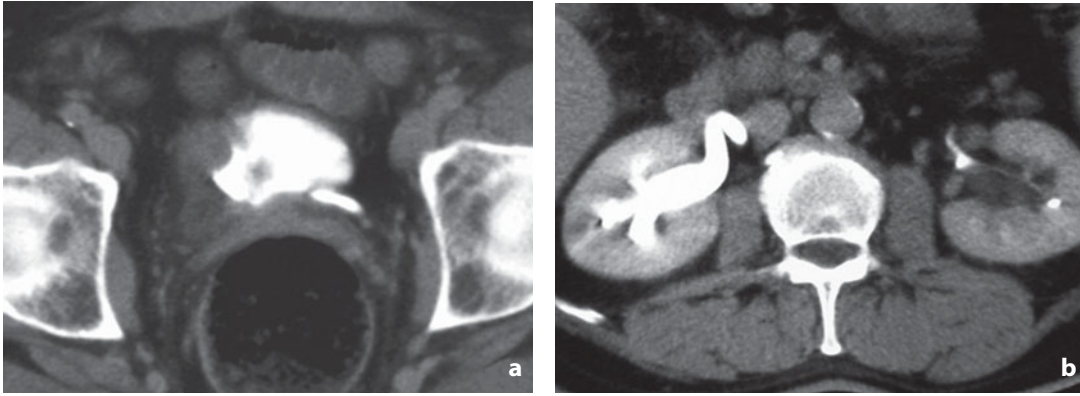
Computed tomography. Bladder cancer. a The late phase of the dynamic study shows wall thickening at the right lateral aspect of the bladder. b The ipsilateral ureteric outlet is probably involved due to retrodilatation of the ureter
